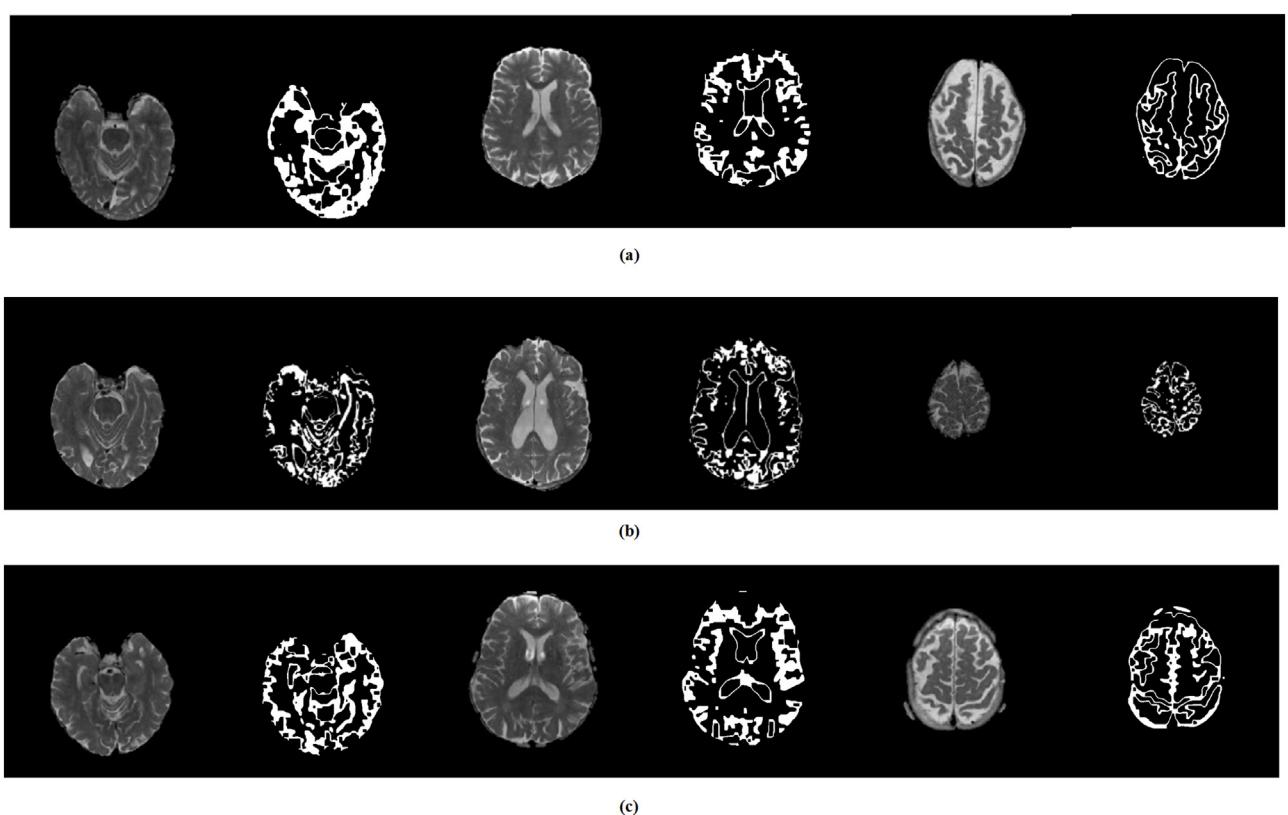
T2 weighted skull stripped image to GM Segmented image (a) AD Skull stripped T2 Weighted MRI image to GM Segmented image (b) MCI Skull stripped T2 Weighted MRI image to GM Segmented image (c) CN Skull stripped T2 Weighted MRI image to GM Segmented image.
